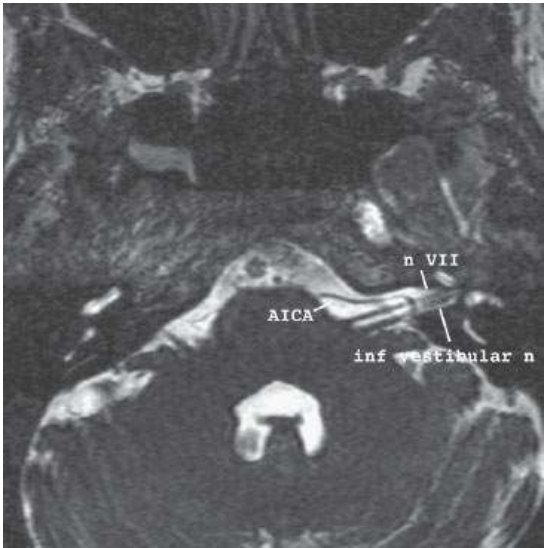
Possible neurovascular compression in a patient with unilateral sensorineural hearing loss. Axial magnetic resonance image (CISS) at the level of the internal auditory canal (IAC) shows the anterior inferior cerebellar artery extending deep into the IAC.
